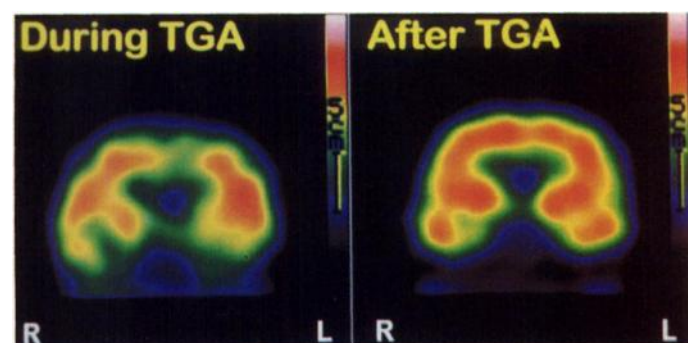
During TGA, Patient 2 exhibits a circumscribed hypoperfusion of the right temporo-medial region and of the entire left temporo-basal region. Less-pronounced hypoperfusion also is seen in the apical region and the basal ganglia (left > right). The follow-up SPECT of the same patient shows a normalized, homogeneous perfusion.
